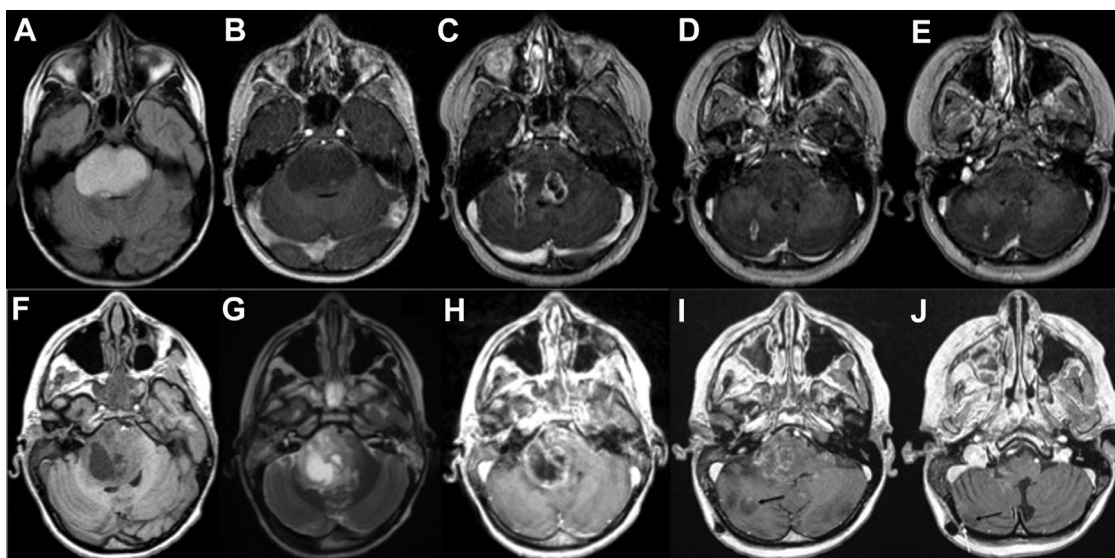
Patient 1. (A) Preoperative magnetic resonance imaging (MRI) in an axial fluid-attenuated inversion recovery (FLAIR) T2-weighted image of a DIPG showing a typical hypersignal and enlargement of the pons. (B) Preoperative MRI in an axial T1-weighted, contrast image of a diffuse intrinsic pontine glioma (DIPG) showing a strictly local disease (hyposignal with a little enhancement in the pons) with no metastasis into the posterior fossa. (C–E) Late postoperative MRI in an axial T1-weighted, contrast image showing the contrast enhancement along the trajectory of the stereotactic biopsy. Patient 2. (F) Preoperative MRI in an axial T1-weighted
